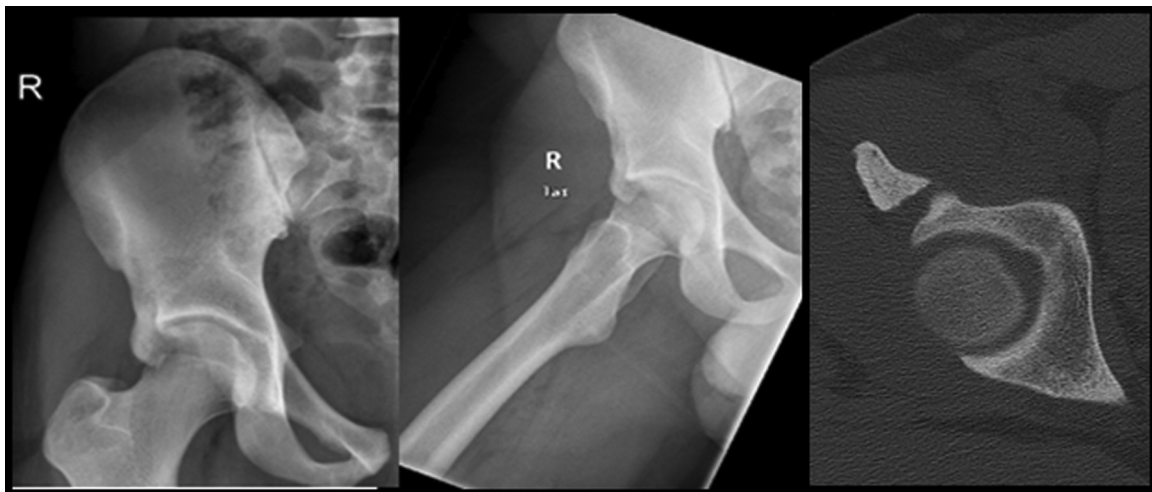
X-rays and CT films of right hip at initial presentation.
